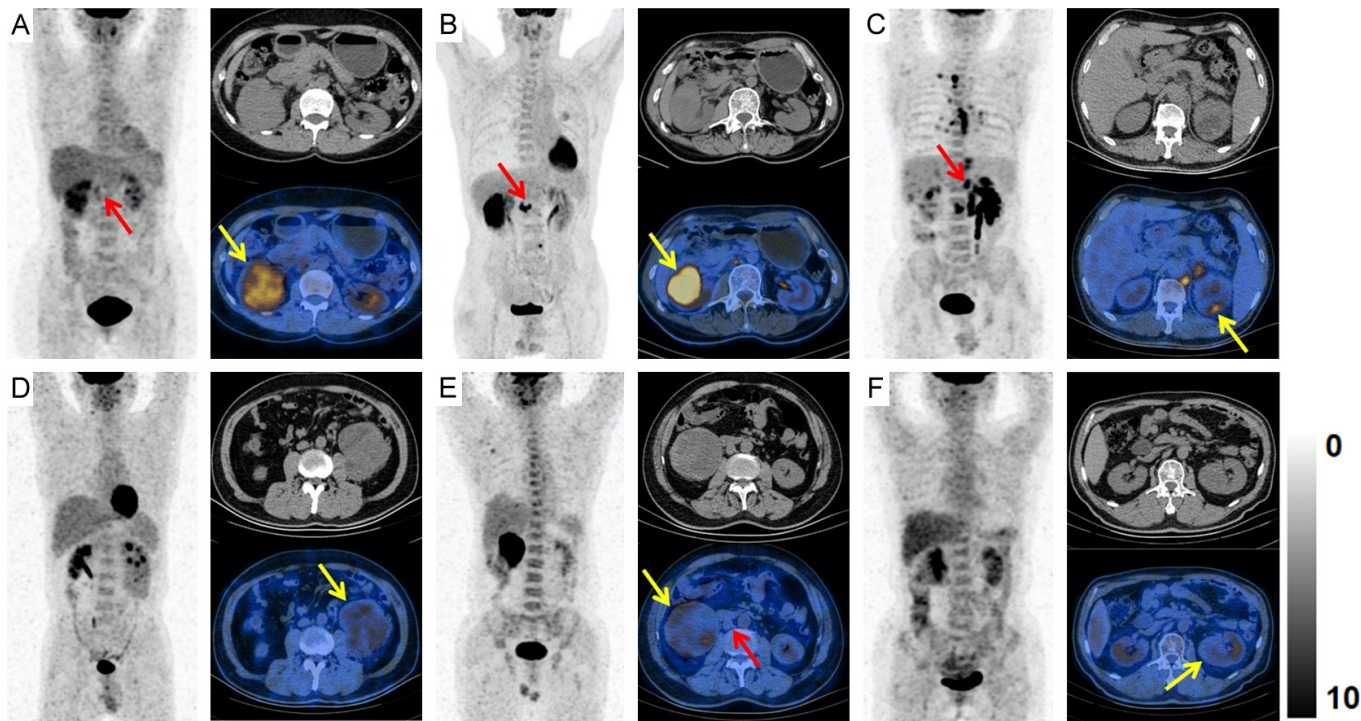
¹⁸F-FDG PET/CT images of the CDC and ccRCC patients with similar primary tumor size. The primary tumors were indicated by yellow arrows and the regional lymph node metastases were indicated by red arrows. A-C. Three CDC patients displayed primary tumor sizes of 61 mm, 72 mm, and 48 mm. The corresponding SUVmax values for these tumors were 5.5, 14.4, and 8.9, respectively. D-F. Three ccRCC patients showed primary tumor sizes of 89, 81 and 46 mm. The corresponding SUVmax values for these tumors were 4.2, 3.8, and 2.6, respectively.
